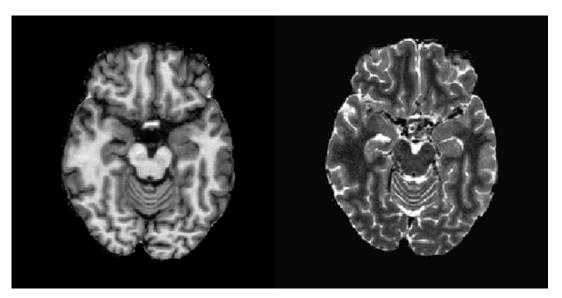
T1-(left) and T2-weighted (right) axial cross-sections for tissue segmentation.
